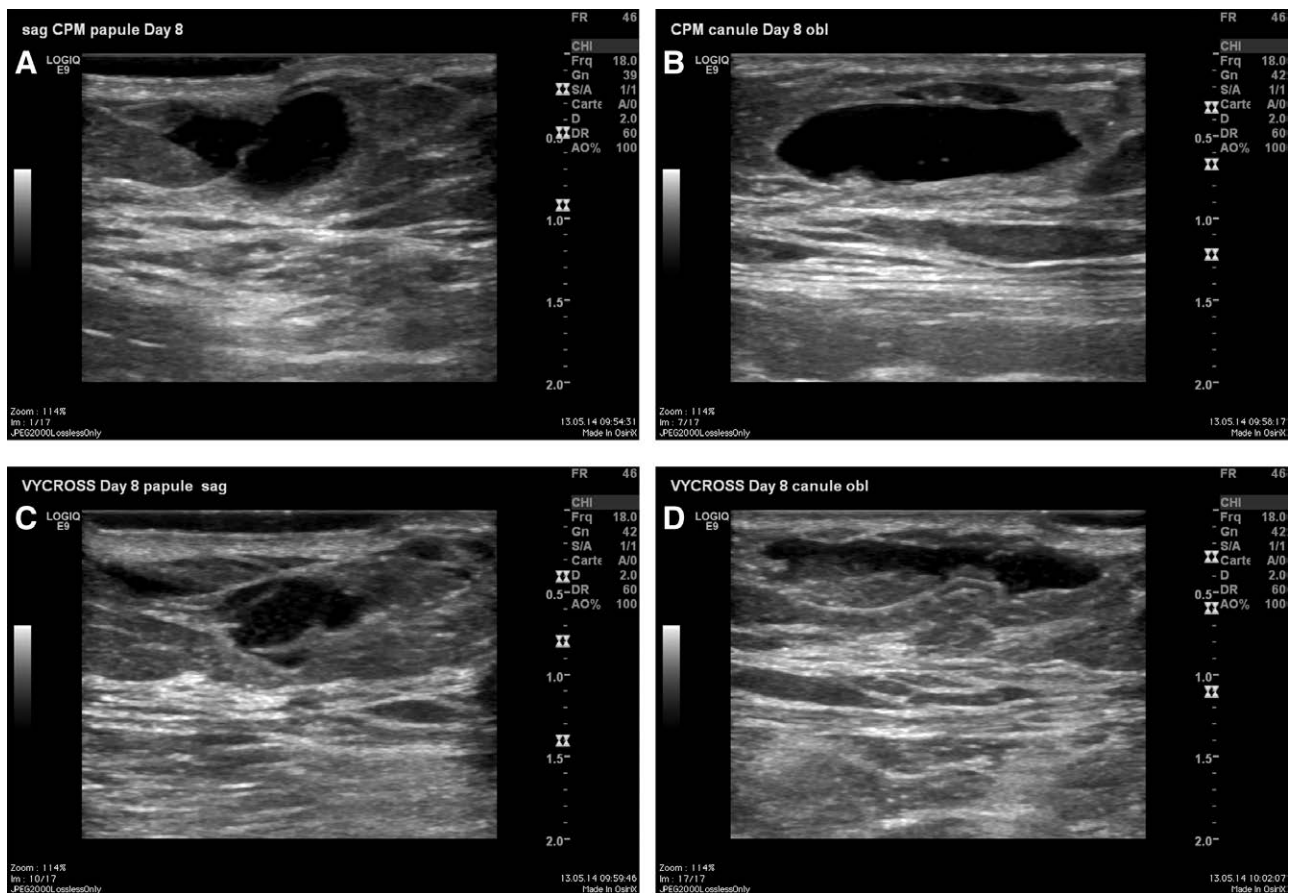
Ultrasound images at day 8 of (A) CPM gel injected by bolus technique, (B) CPM gel injected by retrograde fanning cannula technique, (C) Vycross gel injected by bolus technique, and (D) Vycross gel injected by retrograde fanning cannula technique.
